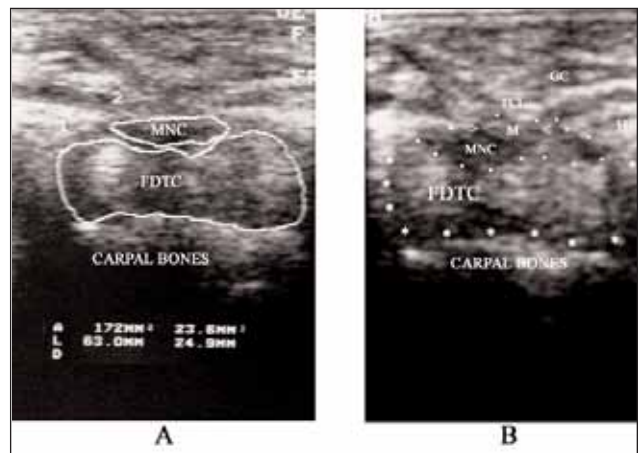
A. Estimation of sectional surface area of MNC and FDTC by using ultrasonography in a normal subject (MNC: Median nerve compartment, FDTC: Flexor digitorum tendons compartment). B. Normal ultrasonographic anatomy was shown in a normal subject.
